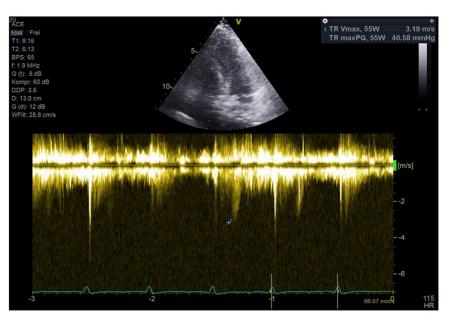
Apical 4-chamber view (right heart centered) during stress echocardiography at 55 watts, continuous-wave Doppler of the tricuspid valve, weak and incomplete Doppler signal slightly above the upper limit (3.2 m/sec) at peak stress. The signal quality is not sufficient to ultimately exclude a slight increase in pulmonary pressure.
